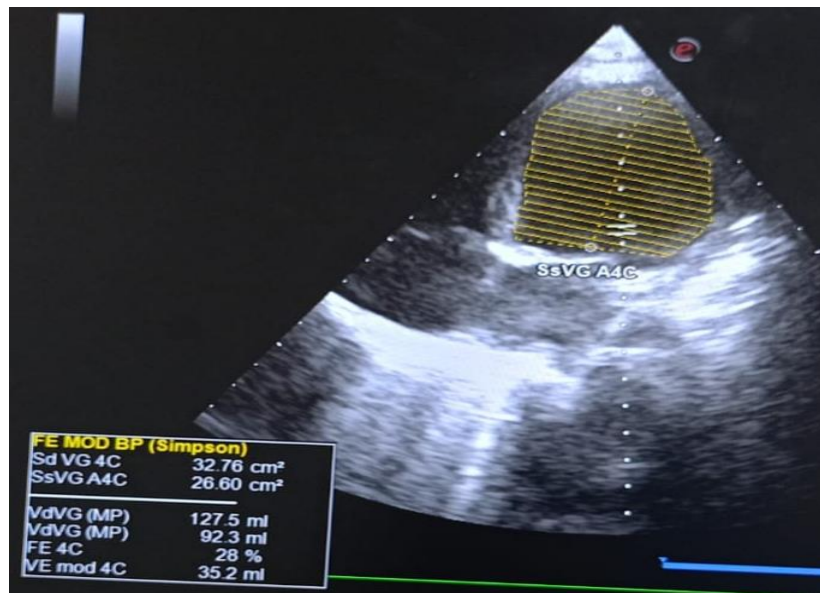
Echocardiogram showing a left ventricle with impaired systolic function and an LVEF of 28%
